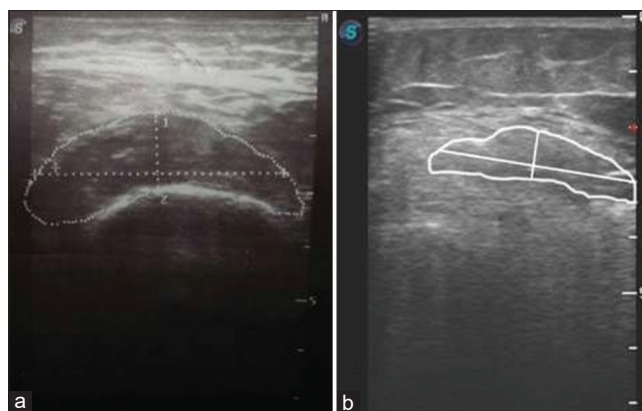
Ultrasound images of the rectus femoris muscle using the superficial linear transducer in a patient on oral nutritional supplement (ONS) (a) and another patient on conventional diet (CD) (b) the picture was taken at POD3
